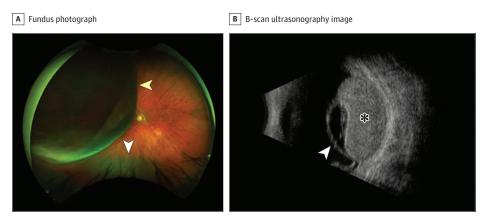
A, Fundus photography showing a partially pigmented choroidal lesion located superotemporally (yellow arrowhead), extending to the macula with associated exudative retinal detachment inferiorly (white arrowhead). B, B-scan ultrasound image of the lesion showing an acoustically solid lesion with prominent intralesional vascularity with an irregular internal structure (asterisk), measuring $26 \times 21 \times 8.1$ mm, with subretinal fluid that overlies the lesion and extends inferiorly (arrowhead) on B-scan.
